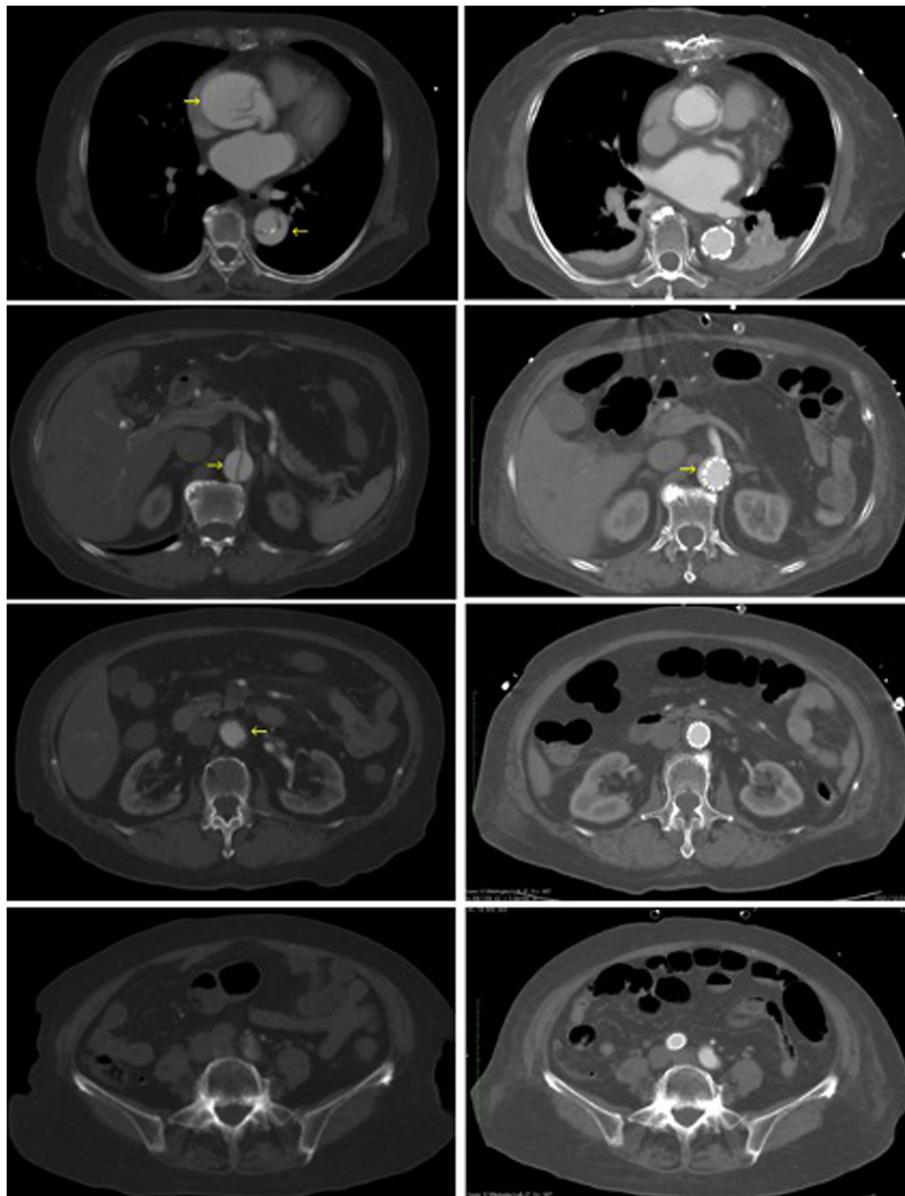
Left: Preoperative CT shows acute type A aortic dissection with SMA dissection and bilateral limb ischemia because of the true lumen collapse. The arrows point to the false lumen. Right: Postoperative CT shows adequate true lumen expansion. SMA and bilateral iliac arteries were well enhanced.
